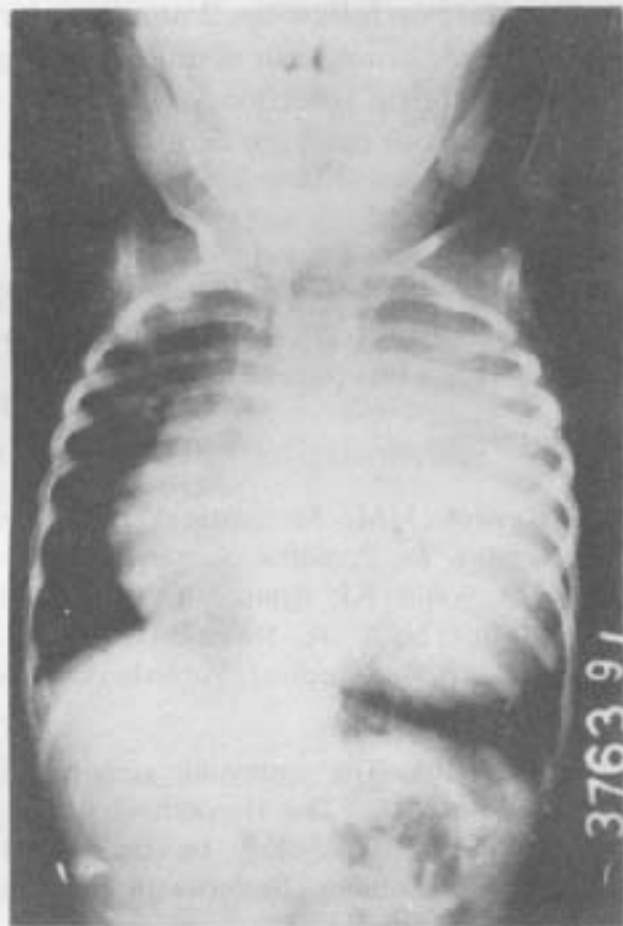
Chest roentgenogram showing intrathoracic mass in the left hemithorax.
